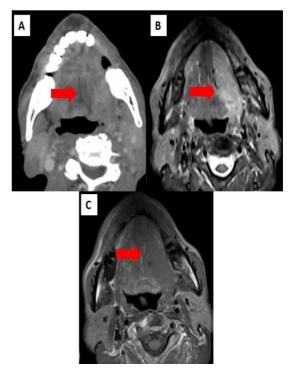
IMAGING FINDINGS: Well-defined soft tissue density lesion heterogeneously enhancing on CECT (4A), hyperintense on STIR (4B) and hypointense on T1WI (4C) involving left base of tongue with anterior extension. The anterior extension is not well depicted on CECT, as it is depicted on corresponding MRI images
